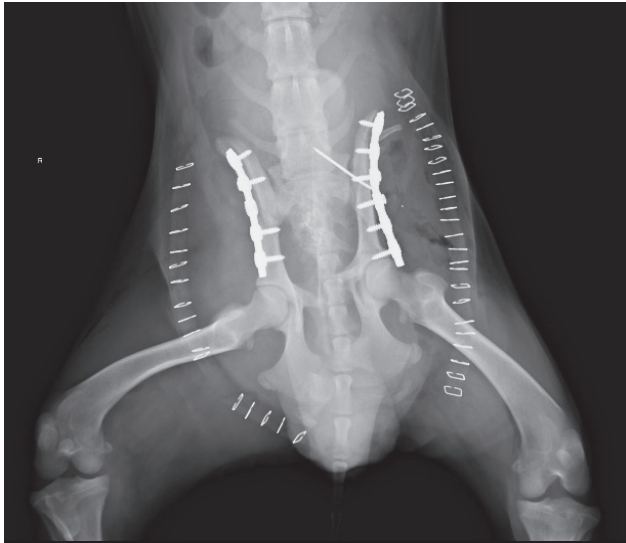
Post operative radiography – restoration of pelvic canal diameter
